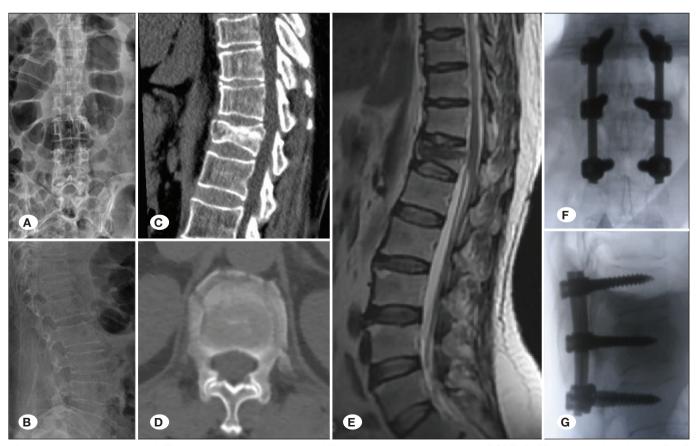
Male, 60 years old, T12 burst fracture caused by falling accident, and performed PSPF. A, B) preoperative X-rays, C, D) Preoperative CT examination, E) preoperative MRI examination, F, G) postoperative lateral X-ray.
